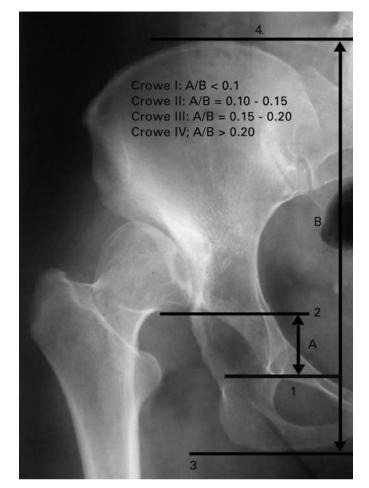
Radiograph showing measurements for the Crowe classification system (A, vertical distance between the reference interteardrop line (line 1) and the head-neck junction (line 2); B, vertical distance between the line connecting the ischial tuberosities (line 3) and the line connecting the iliac crests (line 4)
